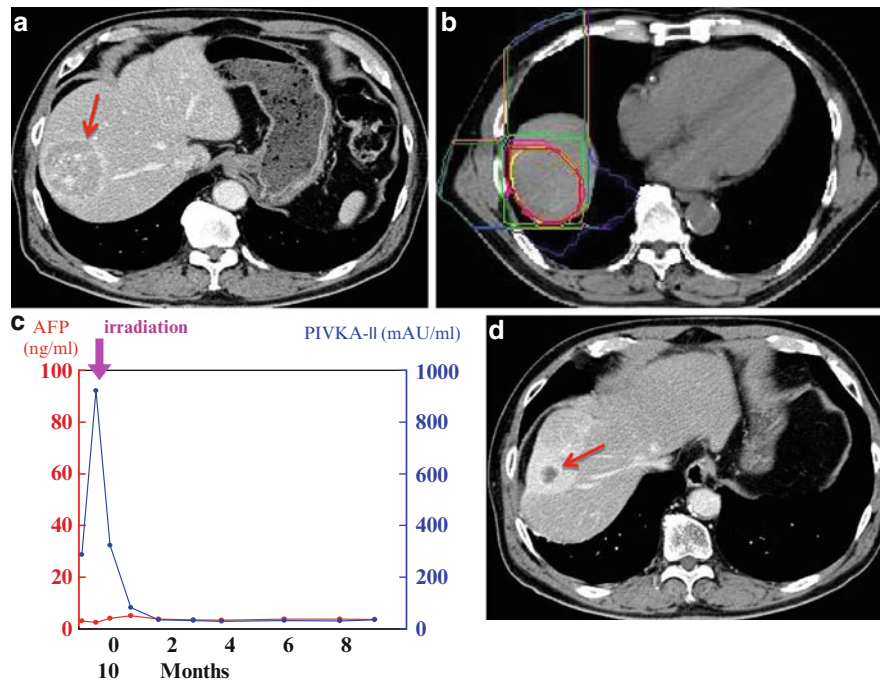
A case with hepatocellular carcinoma 5.5 cm in maximum diameter in the right anterior superior segment of the liver. (a) CT scan before treatment. (b) Dose distribution: The beam was delivered in combination with anterior and lateral portals (dose ratio 1:1). The planning target volume was defined so as to include a 1.2-cm margin around
